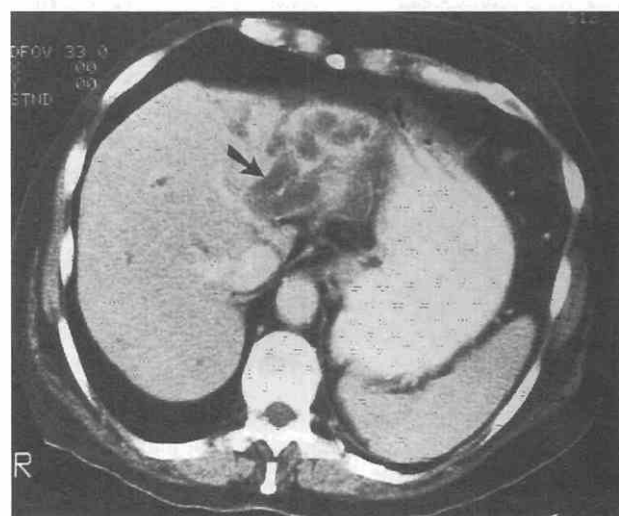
Biliary dilatation (arrow) and atrophy of the left hepatic lobe as a result of cholangiocarcinoma. (From Vazquez JL, Thorsen MK, Dodds WJ, et al: Atrophy of the left hepatic lobe caused by a cholangiocarcinoma. *Am J Roentgenol* 144: 542, 1985.)
